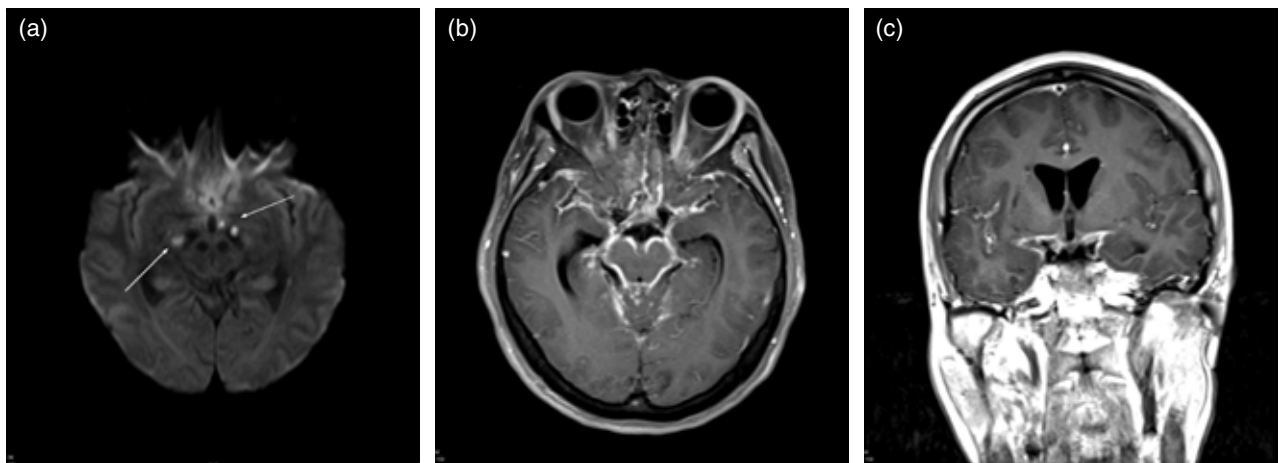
Axial diffusion-weighted image (a) reveals acute infarctions in the hypothalami and midbrain on both sides of the brain. Gadolinium-enhanced T1 axial and coronal MRI images (b and c) shows marked, diffuse leptomeningeal enhancement over the basilar cistern and right sylvian fissure and hydrocephalus.
